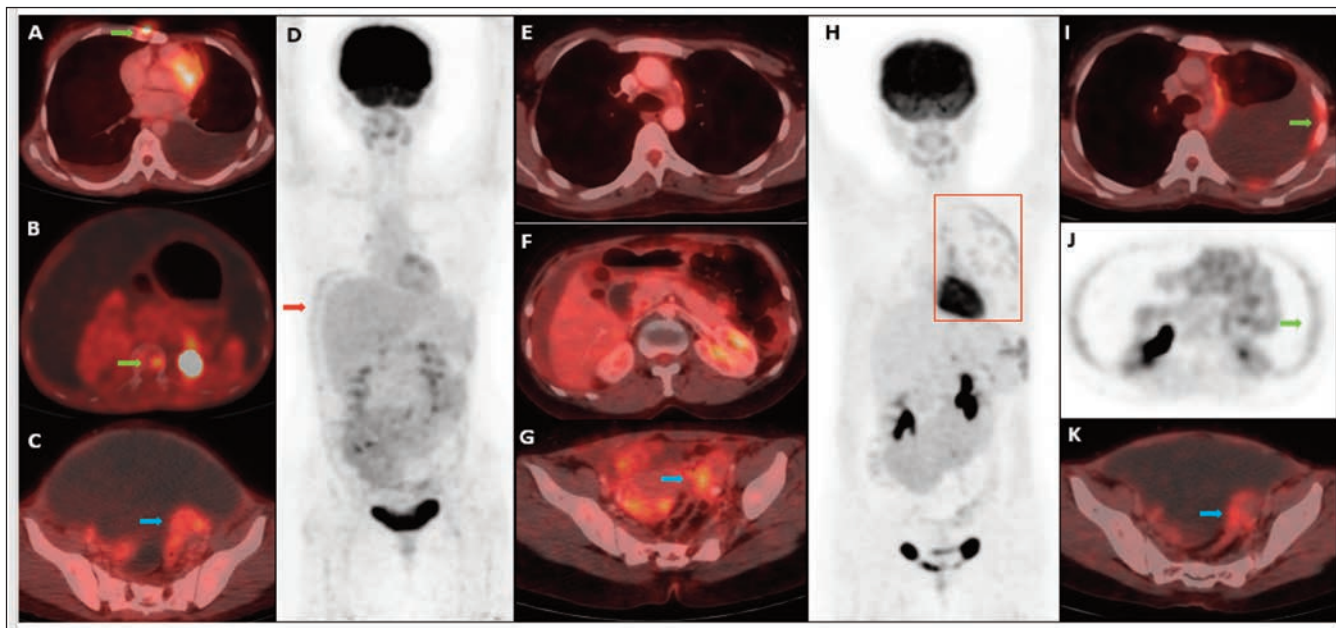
Initial ¹⁸FDG PET-CT showed avid multifocal osseous metastases [Fused axial, green arrows A, B] along with avid bilateral adnexal masses [C, green arrow]. Follow-up PET/CT 2 years later showed avid peritoneal nodularity and omental thickening [Maximum intensity image, MIP; D red arrow]. Subsequent PET-CT showed no abnormal pleural nodularity however; residual avid adnexal lesions were seen [Fused axial images; E-G]. A year later, a follow-up scan revealed interval development of avid pleural nodularity [H-J red box and green arrow] and avid residual adnexal lesion [K, blue arrow].
